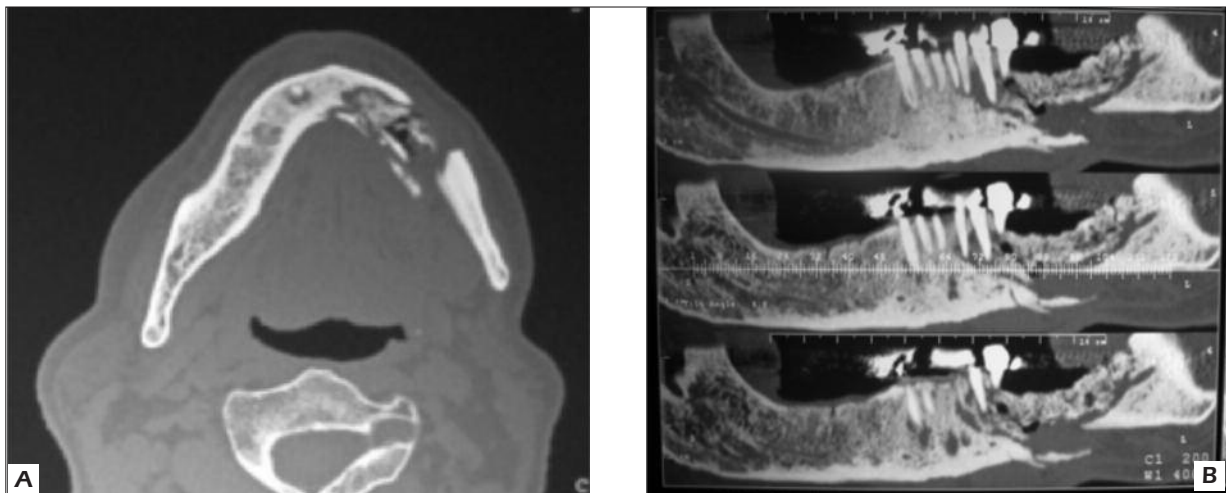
A and B, Patient 2: Assial CT and Dentascan sections of the mandible showing lytic lesion of the left emimandible associated to wide bone sequestra and pathological fracture.
